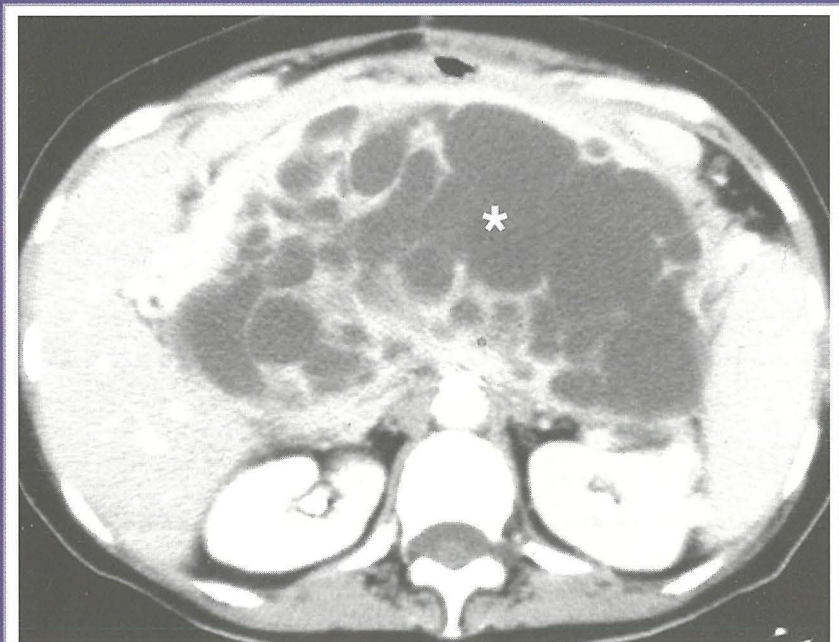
A retroperitoneal fibrohistiocytoma (*) mimicking a pancreatic mass on CT scan; this was initially diagnosed as a mucinous adenocarcinoma of the pancreas
